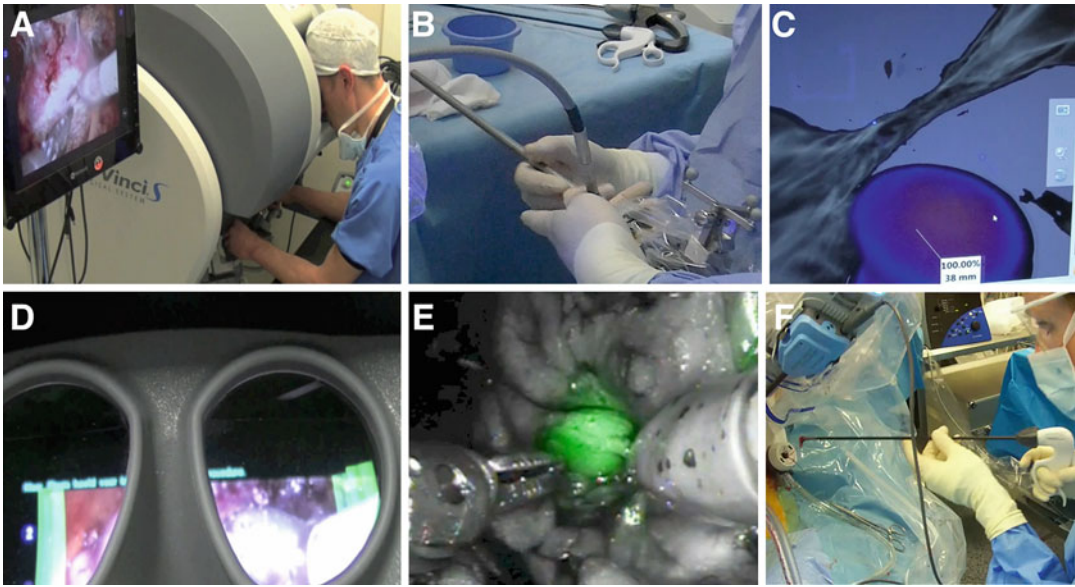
Robot-assisted sentinel lymph node procedure following administration of ^{99m}Tc -nanocolloid into the prostate (a). A tracked laparoscopic freehand SPECT device (b) provides depth information for intraoperative
